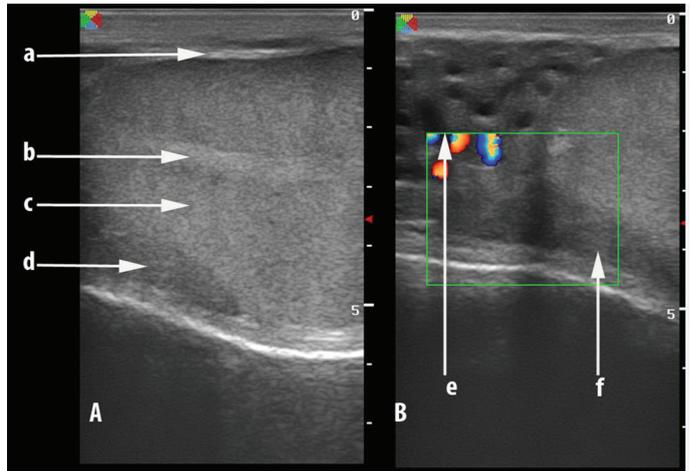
Normal ultrasonogram of the testis and head of the epididymis. Left panel A): a) tunica vaginalis and albuginea, b) rete testis or mediastinum testis, c) testicular parenchyma, d) head of the epididymis. Right panel B: e) testicular artery, f) head of the epididymis
